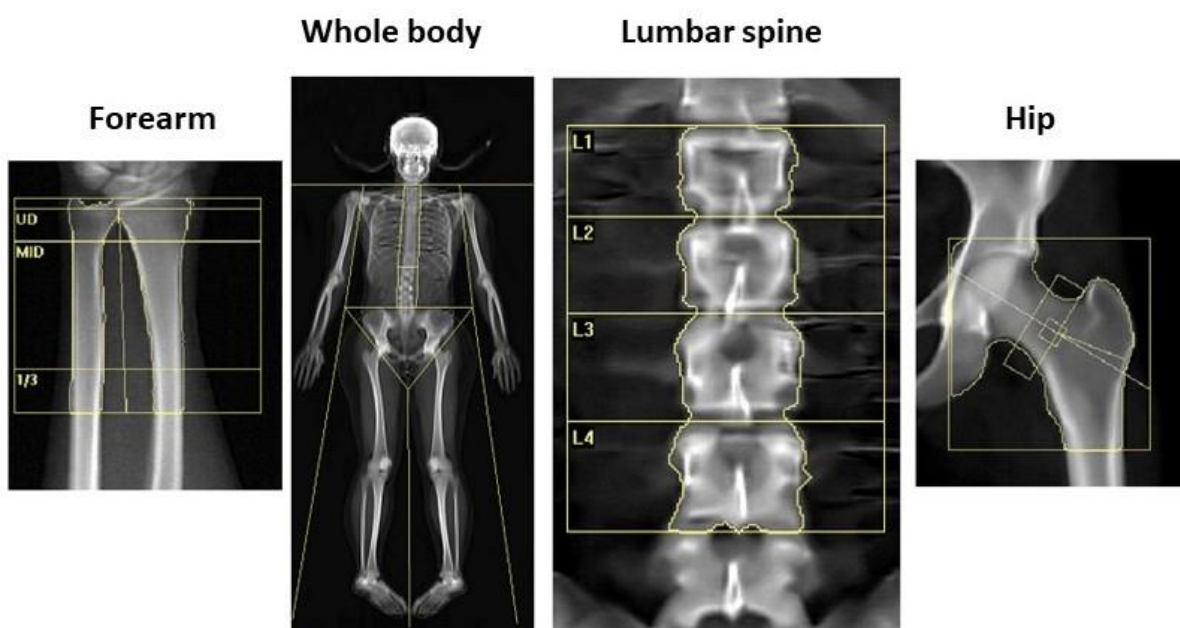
Dual-energy X-ray absorptiometry.
